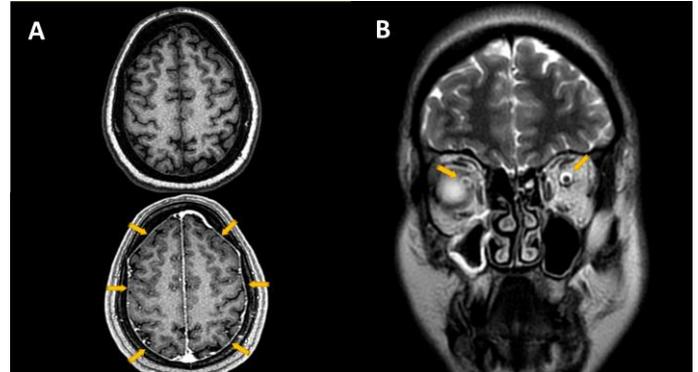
A; Axial section of T1 weighted of brain MRI shows dural enhancement, B; Coronal section of T2 weighted of brain MRI shows the optic nerve sheaths are dilated.
